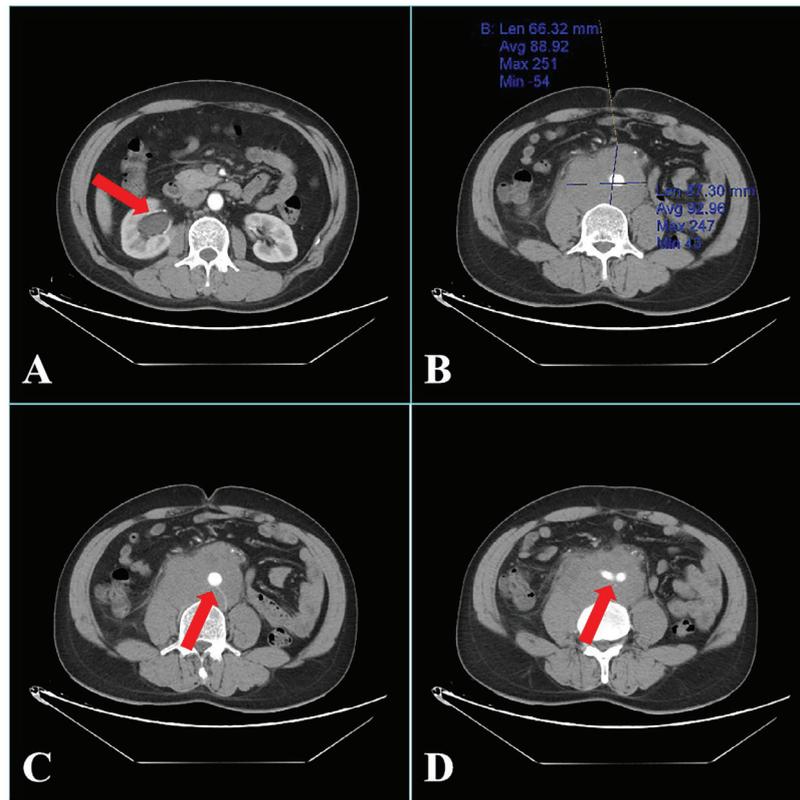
Computed tomography scans showing (A) the right hydronephrosis and (B) a retroperitoneal mass of ~6.6x8.7-cm surrounding the (C) abdominal aorta and (D) bilateral iliac vessels extending downward.
